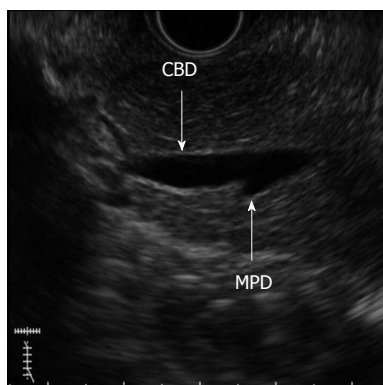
A 56-year-old female with pancreaticobiliary maljunction without choledochal cyst. Endoscopic ultrasound image shows pancreaticobiliary maljunction. CBD: Common bile duct; MPD: Main pancreatic duct.
